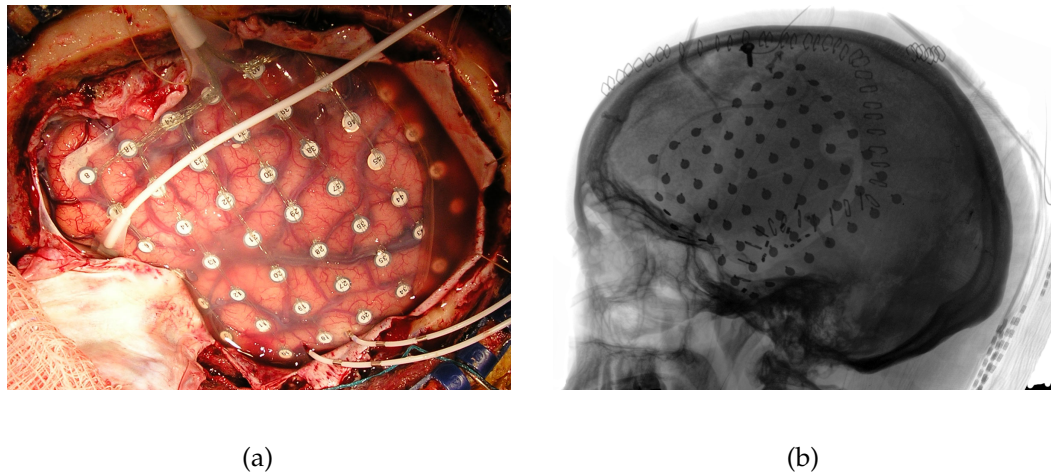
(a) Example of a typical frontotemporal ECoG montage in an intractable epilepsy patient. The implant consists of an 8×8 electrode grid with 10 mm center-to-center spacing between electrodes. (b) Lateral X-ray radiograph of the same patient showing electrode locations. The surgical photograph was used to annotate the locations of visible electrodes on an MRI rendering, while the coordinates of hidden electrodes were found using X-ray backprojection to the MRI-derived brain surface (Dalal et al., 2007a).
